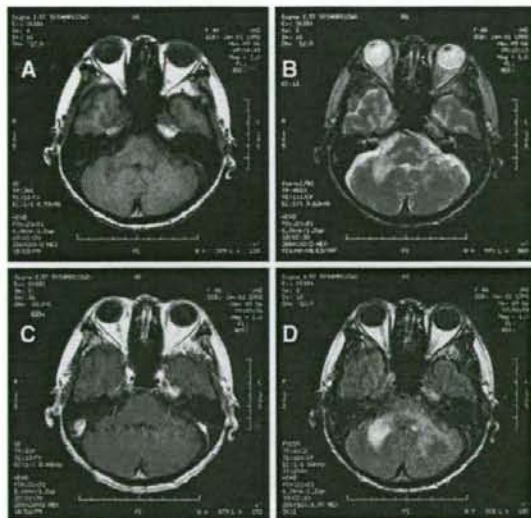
December 2006: magnetic resonance imaging showing cerebellar atrophy in a T1-weighted image (a), white matter abnormality and expansion into the region of the adjacent brainstem in a T2-weighted image (b), cerebellar atrophy without areas of enhancement in a T1-weighted image (c), and white matter abnormality and expansion of the region of the adjacent brainstem in fluid-attenuated inversion recovery (d)
